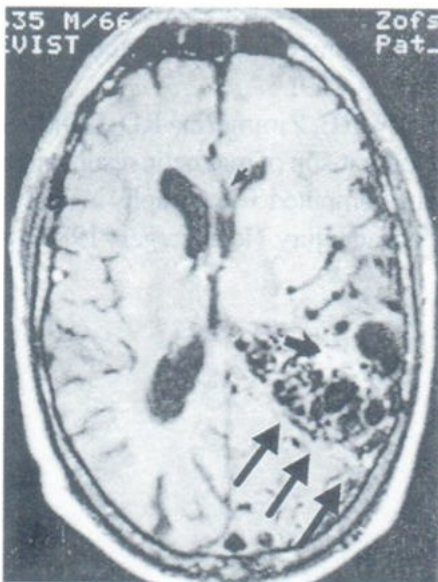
NC.CT. showed Arterio-Venous Malformation (AVM) at left side of the brain (black arrows).
